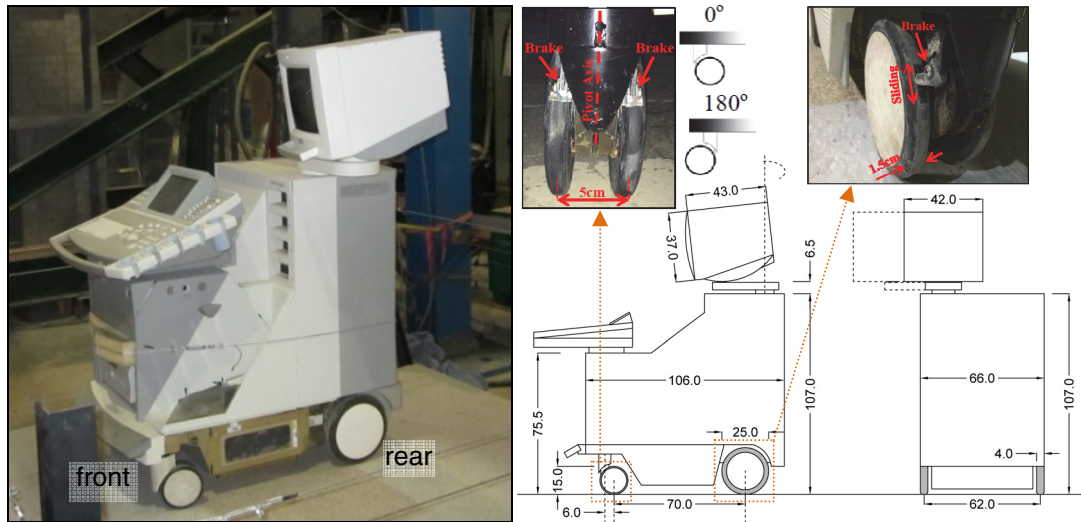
Ultrasound machine supported on wheels (rear) and twin-wheel casters (front). Dimensions in cm.
